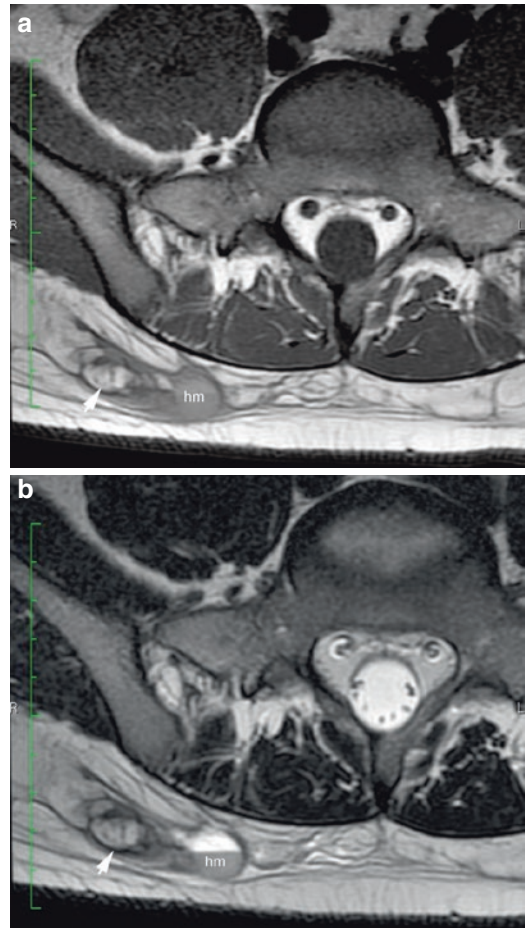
(a, b). Fat necrosis on MRI (axial views). (a) T1-weighted sequence shows isointense pseudonodule with a hypointense rim located in the hypodermis of the right side of the lower back (arrow, fat necrosis area). In the vicinity, a hypointense oval-shaped hypodermal structure is detected that corresponds to a hematoma (hm). (b) T2-weighted image of the same case shows a change in the intensity of the hematoma (hm) with a fluid–fluid level (hyperintense/hypointense) and no change in the intensity of the pseudonodule (arrow, fat necrosis site) in comparison with the T1-weighted sequence (Courtesy of Drs. Raul Valenzuela and Herly Pulgar)
